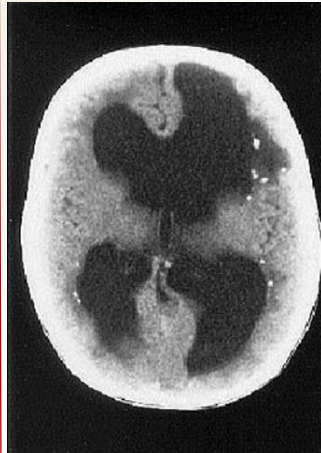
Cranial CT scan of infant born with symptomatic congenital cytomegalovirus infection. Neurological involvement is evident as manifested by ventriculomegaly and periventricular calcifications. (Schleiss, 2015).
